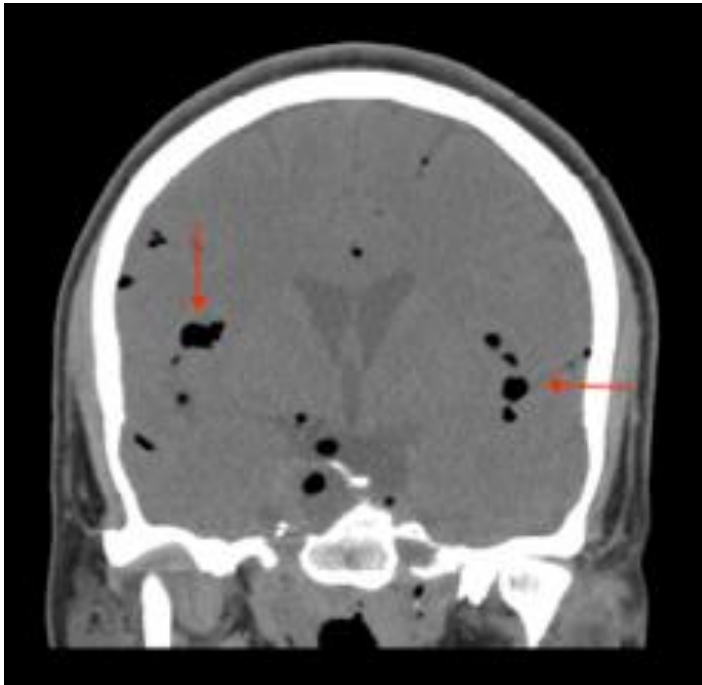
Coronal view from head computed tomography without contrast demonstrating subarachnoid air. Red arrows indicate collections of hypoattenuation, representing air in the subarachnoid space.
